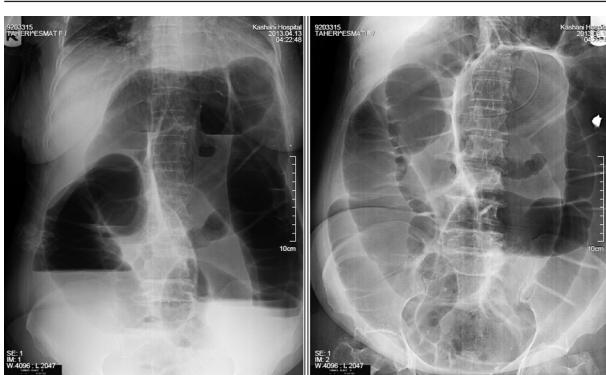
Plain Abdominal X-ray Delineates Intestinal Loop Distension
